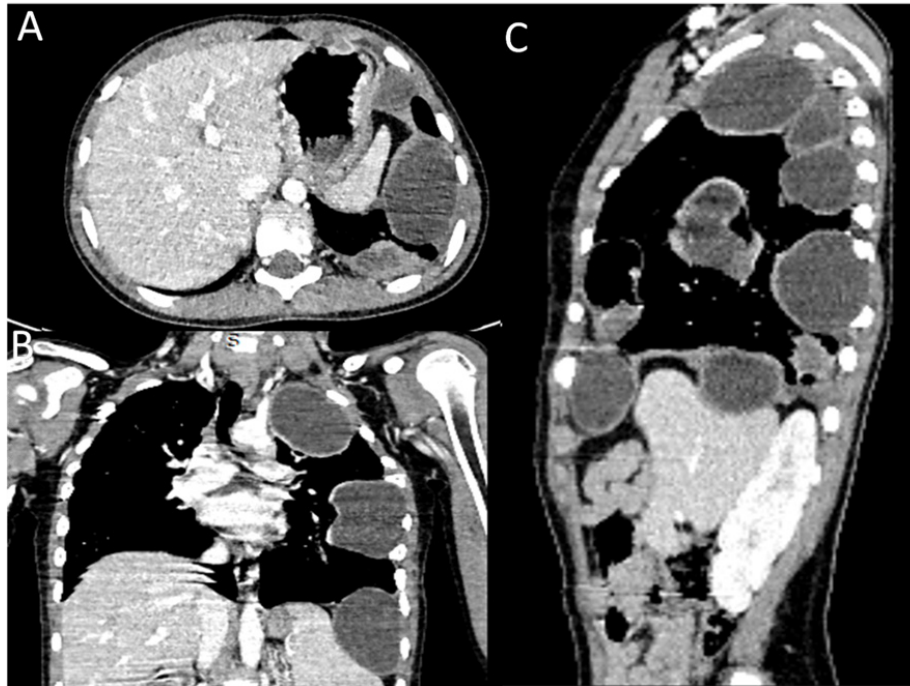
A axial, B coronal, and C sagittal enhanced chest CT demonstrating multiple hypodense cystic lesions along the left costal pleura with mass effect on the spleen.
